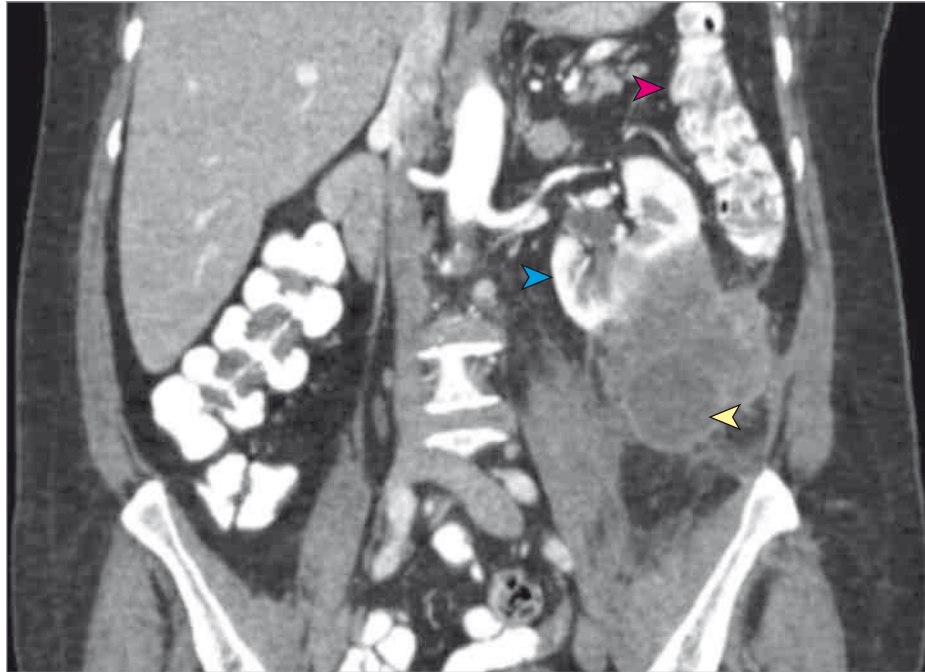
Coronal computed tomographic image showing a retroperitoneal mass with a cystic component and involvement of adjacent kidney and mesocolon. Red arrowhead indicates descending colon; blue arrowhead, left kidney invaded by mass; and yellow arrowhead, retroperitoneal mass with cystic component.
